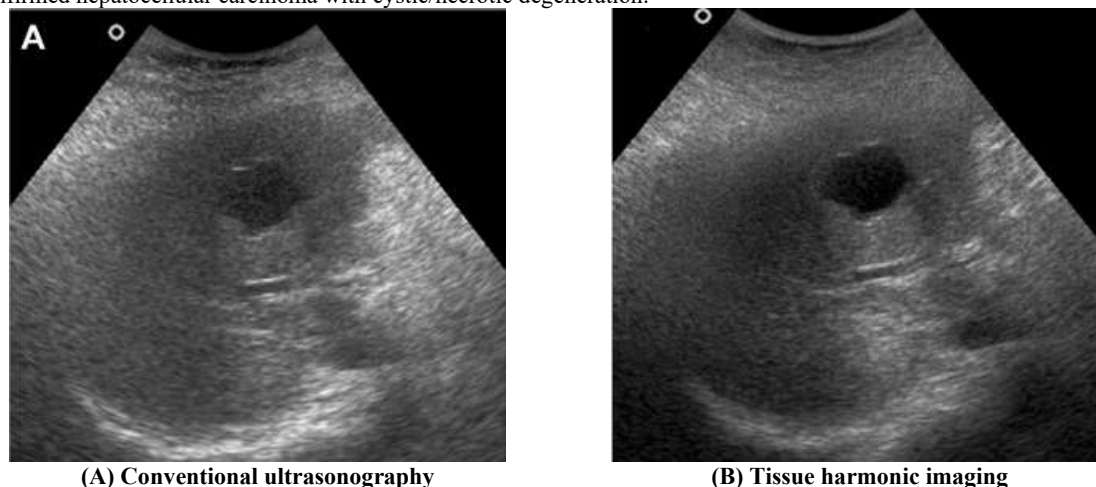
A 58-year-old man with right hypochondrial pain and weight loss. (A) Conventional ultrasonography shows a relatively well-defined, heterogeneously hypoechoic lesion with a suggestion of an internal cystic component and slight posterior enhancement, giving the impression of a cystic lesion; artefacts were prominent with reduced overall image quality. (B) Tissue harmonic imaging shows the same lesion with improved margins, a solid internal architecture and no posterior enhancement, consistent with a solid lesion and allowing greater diagnostic confidence.
